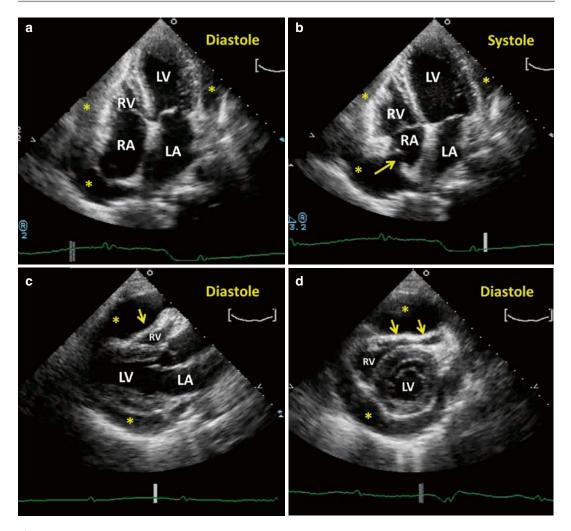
Tamponade: 2D echocardiographic findings. Transthoracic echocardiogram demonstrates tamponade physiology in a young woman with metastatic breast cancer and a large pericardial effusion (*asterisks*). Panels a, b: Apical 4-chamber views demonstrate right atrial physiology in tamponade. Characteristic bucking (collapse) of the right atrial free wall occurs during ventricular systole (Panel b) but not during ventricular diastole (Panel a).
